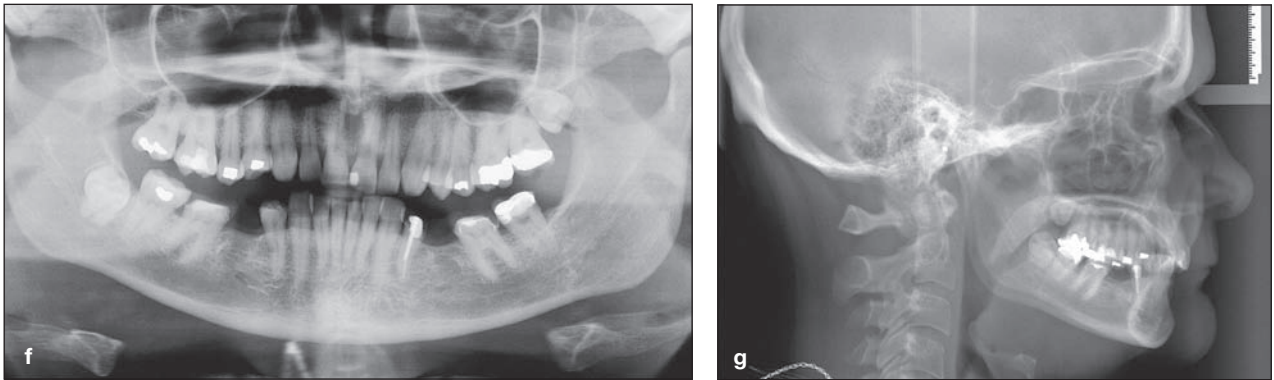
(cont) (f) Preoperative panoramic radiograph. (g) Preoperative cephalometric radiograph. →
